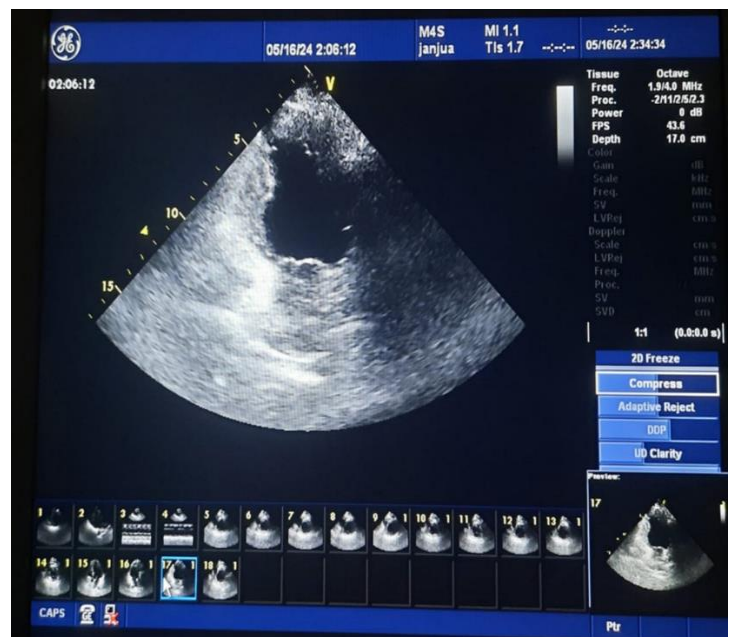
The echography on admission; Parasternal short axis view showing hypokinesia of infero posterior segment with aneurysm formation.
